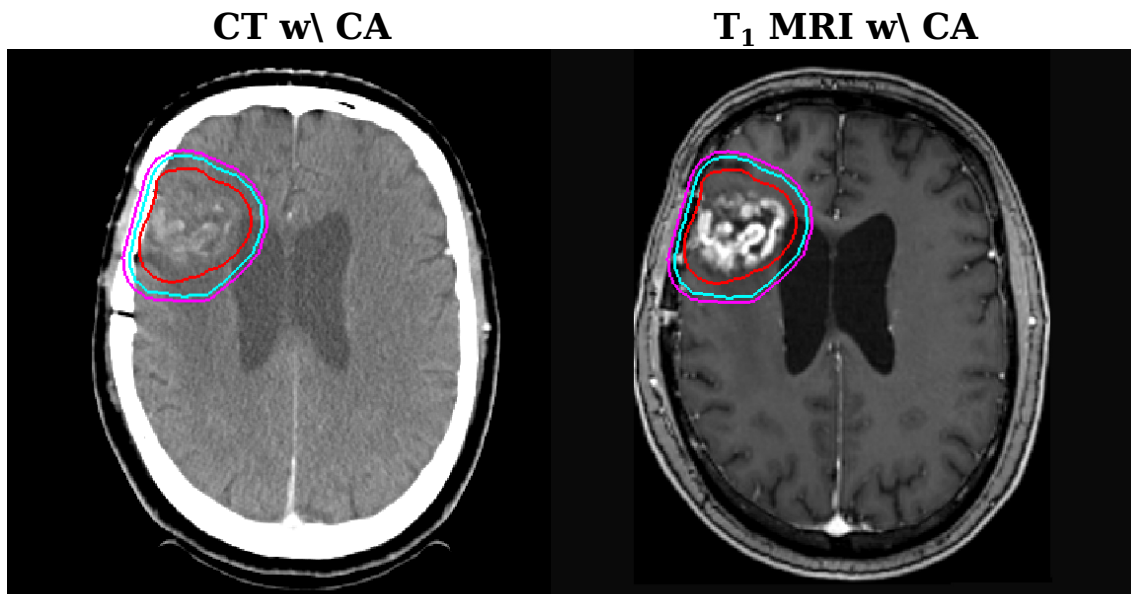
RT planning target contours gross tumor volume (red), clinical target volume (cyan) and planning target volume (magenta) of a brain tumor patient, displayed in the contrast enhanced planning CT (left) and the contrast enhanced T_1 weighted MRI (right).
